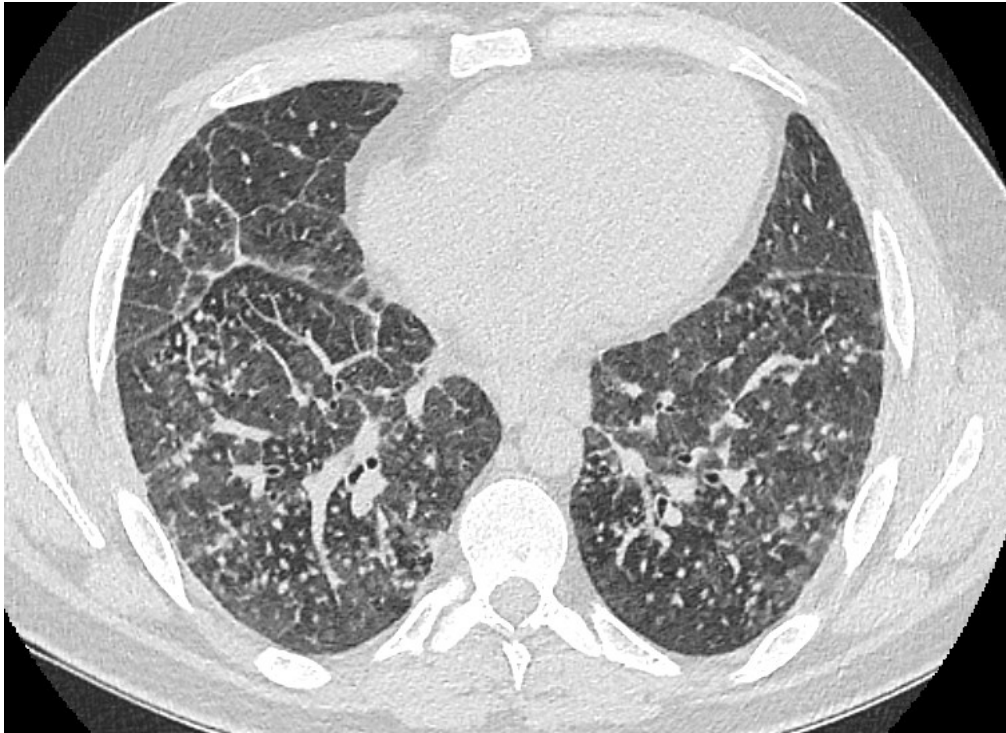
Accelerated silicosis (CXR and CT) with a range of different appearances including bilateral symmetrical soft centri-lobular and some hyperdense small nodules (<1cm diameter) and conglomerate nodules (>1cm diameter). Subpleural nodules and beading along the fissures also seen.
